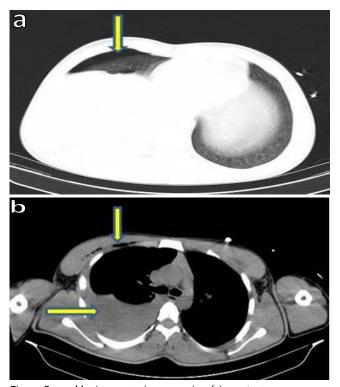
A computed tomography of the patient
